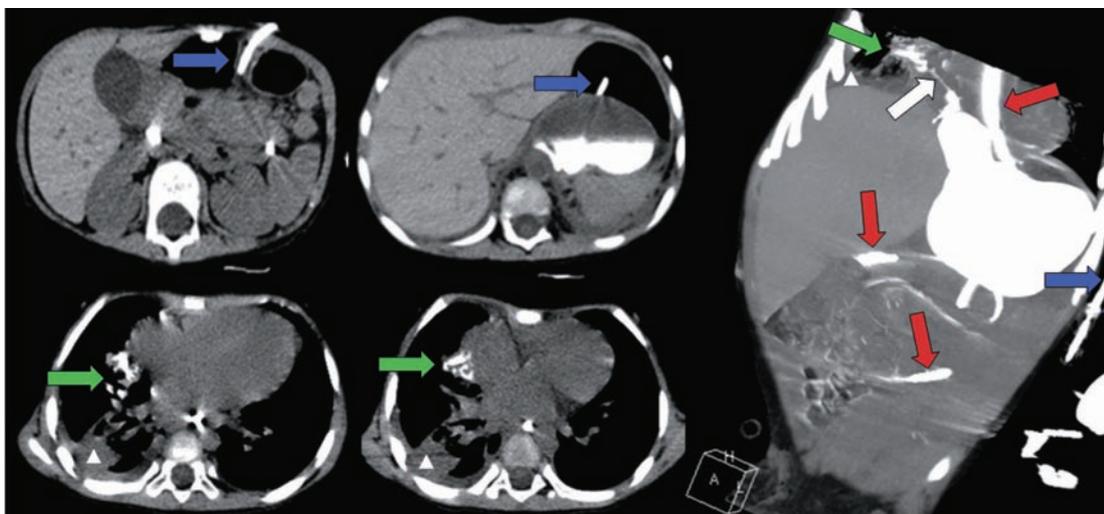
CT with contrast reveals a fistula (white arrow) goes from the cyst up to mediastinum, a jejunal nutrition tube (light grey arrows), pleural effusion (white triangles) and a drainage tube (black arrows), also, the contrast appears in the chest cavity (dark grey arrows).
